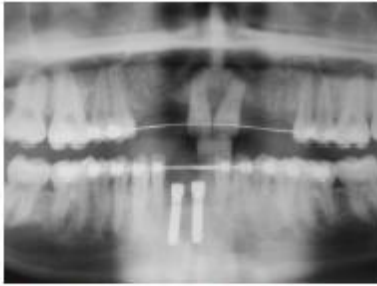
Orthopantomogram in resorption phase following extraction of the expendable ankylosed deciduous teeth.
